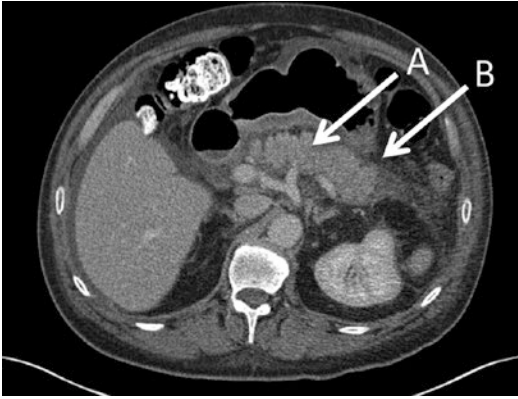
Axial contrast-enhanced CT showing a mildly enlarged pancreas (A), with normal contrast enhancement and peripancreatic fat stranding and fluid (B), consistent with acute interstitial edematous pancreatitis
